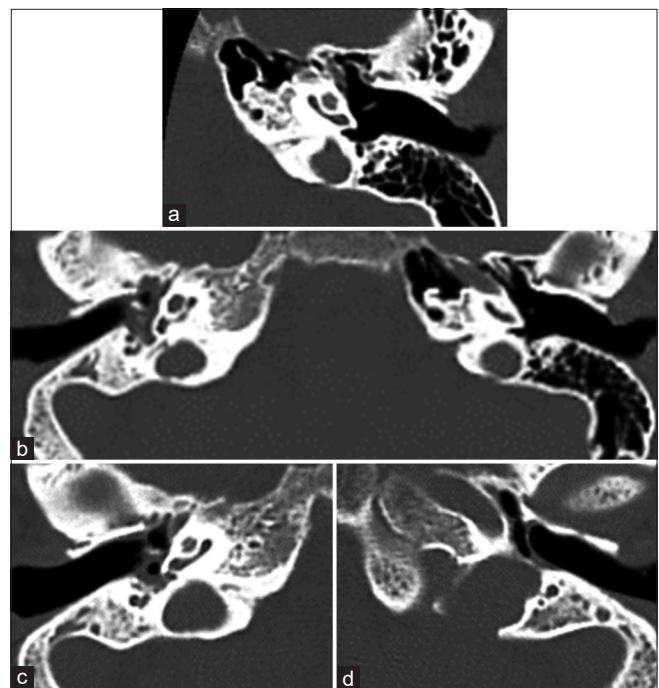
Bilateral high-riding jugular bulb (JB), left JB Diverticula, left JB dehiscence. Case 3: High-resolution computed tomography B/L temporal bone of 81-year-old female. (a) Axial section: Left high JB with diverticula (b) Axial section: Bilateral high jugular bulbs (c) Axial section: Right JB above the level of cochlea (d) Axial section: Left dehiscent JB
